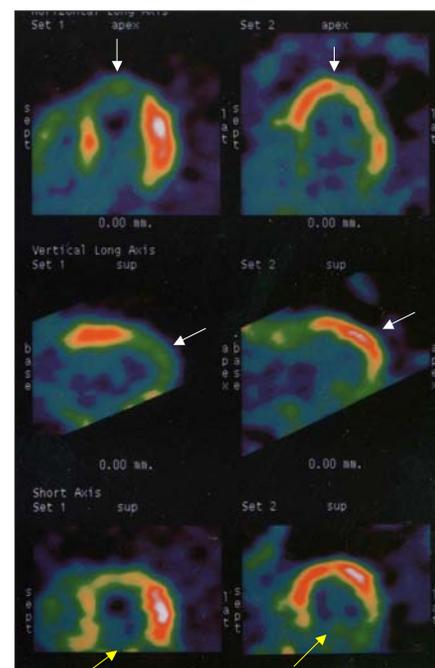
On left, *Rb-82* Perfusion Images. On right, *18-FDG* Metabolic Images.
